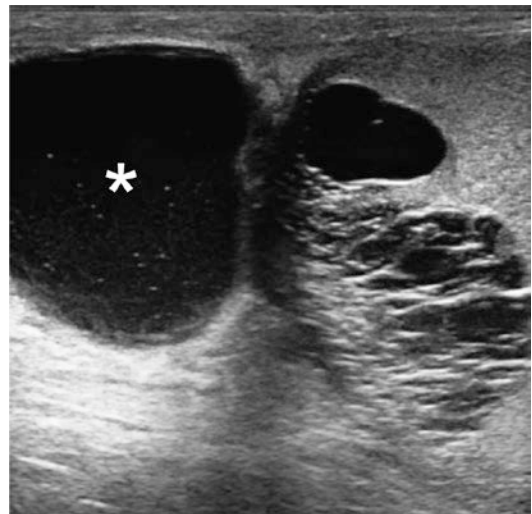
Tubular ectasia of the rete testis. Longitudinal ultrasonographic view showing multiple cystic or tubular anechoic structures localized in the testicular mediastinum. An extratesticular spermatocele is associated (*asterisk*)
